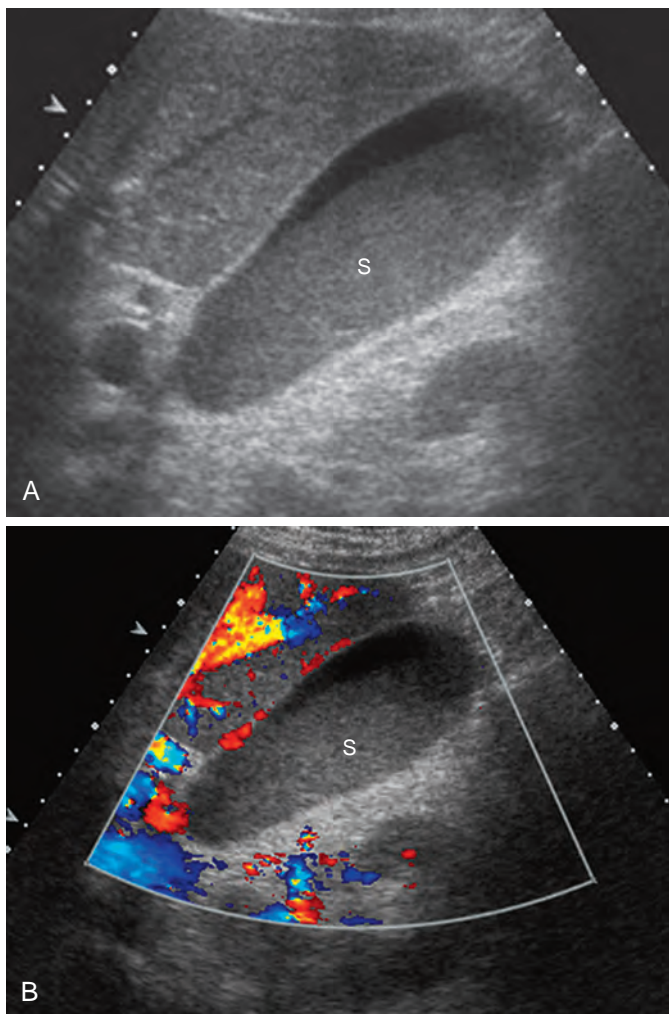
Sludge: sonographic findings. A. Ultrasound shows low-level, nonshadowing intraluminal echoes (s). B. Color Doppler shows no vascularity in sludge (s), helping to exclude a solid, intraluminal mass.
